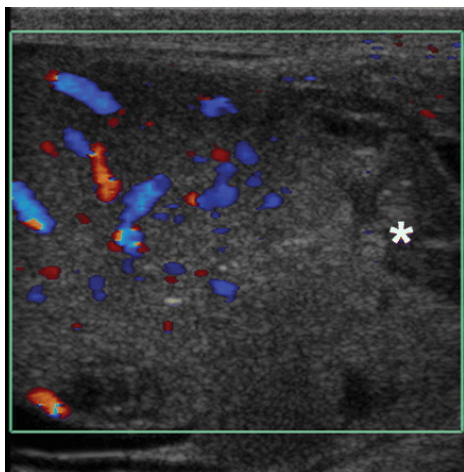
Color Doppler US image depicts an absence of vascularity in the extruded lower pole of the testis. Surgical débridement of the inferior pole was performed with salvage of the uninjured part of the testis
